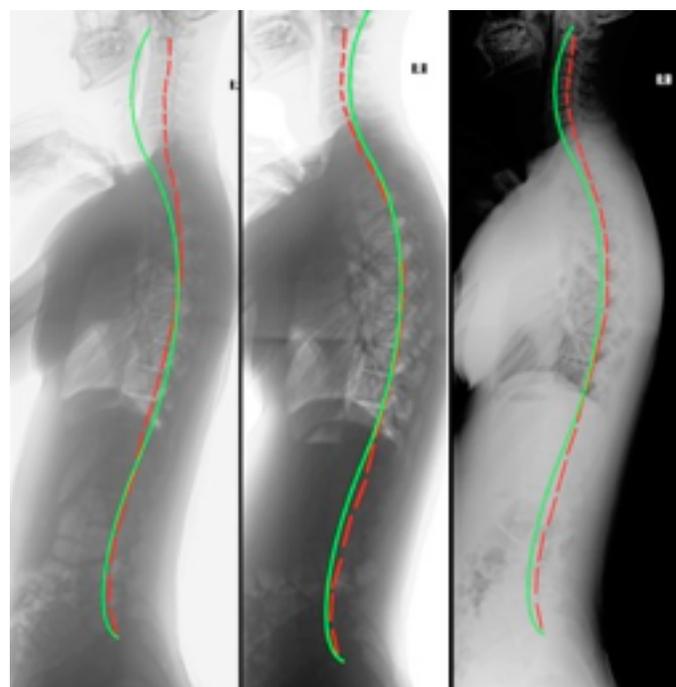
Lateral full-spine radiographs. Left: Initial (1/3/18) image showing thoracic hypokyphosis or 'straight back syndrome;' Middle: Post-treatment (3/7/18) showing increase in thoracic curvature; Right: Follow-up (7/16/18) showing maintenance of structural improvements.
